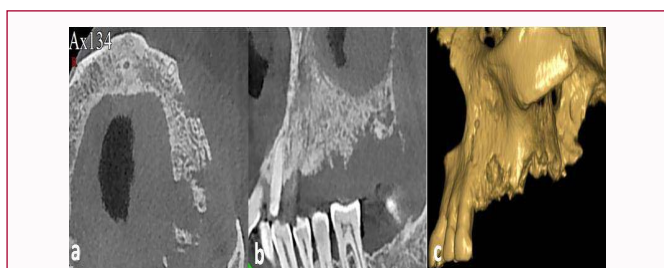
CBCT sections, a) Axial section b) Sagittal sections c) 3D images.
